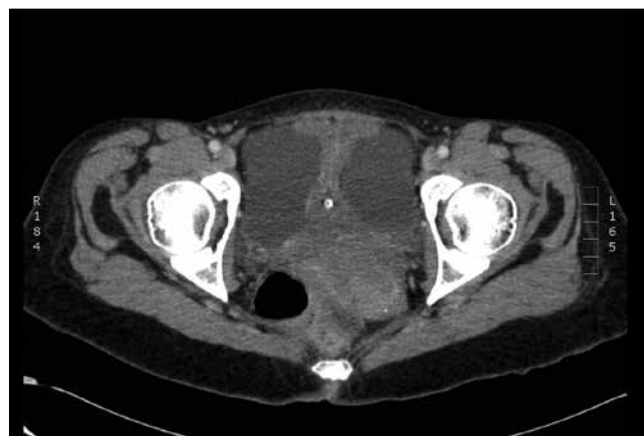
CT scan of the pelvis showing free fluid around a collapsed empty bladder with the catheter tip within.
